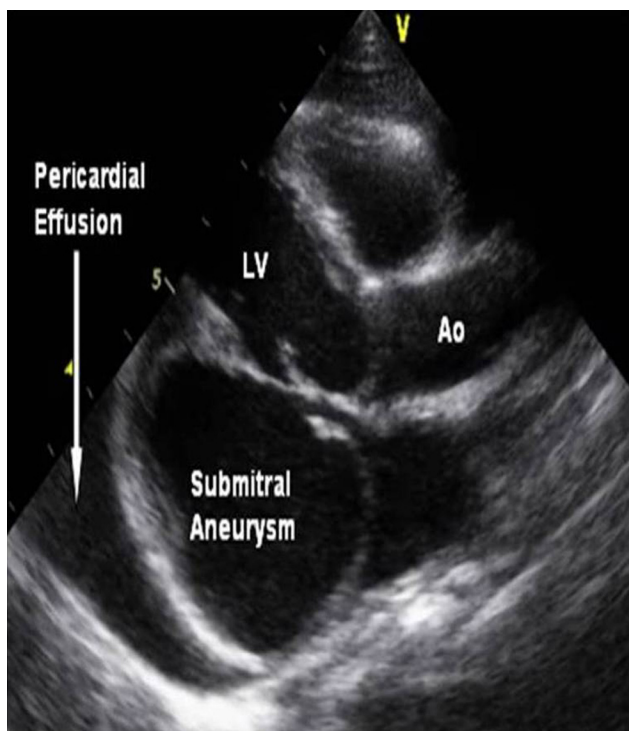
2D echocardiography image in parasternal long axis views showing a thin-walled submitral aneurysm along with pericardial effusion.
